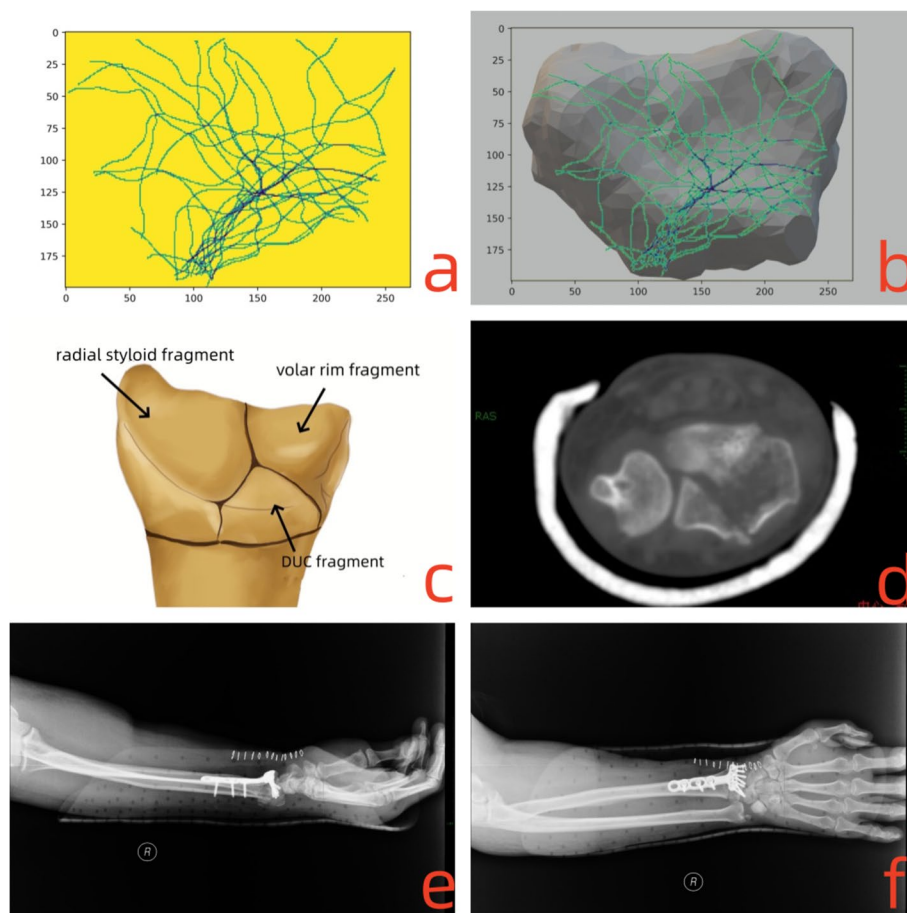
For type 2.1 DRFs, the fracture lines originated from the sigmoid notch and extended to the dorsal and volar side of the articular surface forming a distinctive “└” shape. The morphological characteristics and the clinical treatment were shown as follows: a-b) the fracture lines clustered and covered on the intra-articular surface; c) the model for type 2.1 DRFs; d) the CT scan for the fracture lines at the articular surface; e-f) postoperative posteroanterior and lateral X-ray images
